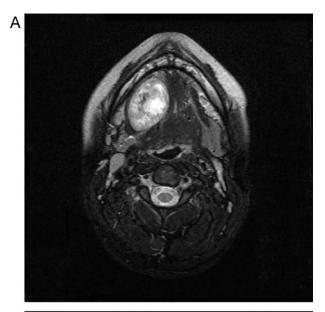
T1-weighted magnetic resonance imaging showing a well demarcated, ovoid, homogenous mass. A: axial view, B: coronal view.
